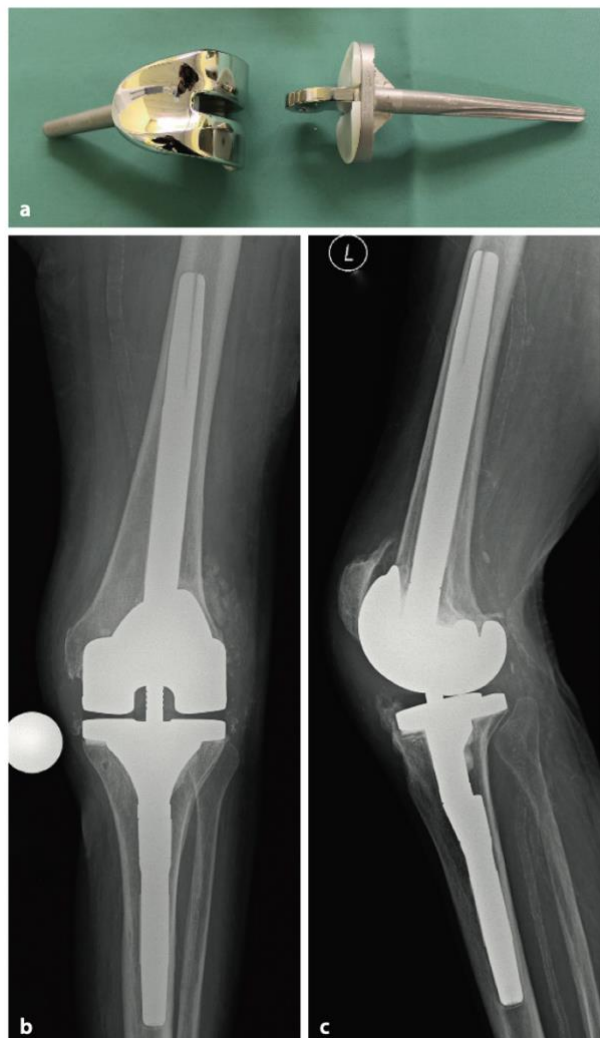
Partially coupled total knee arthroplasty a) Photo; b) and c) X-rays (33)
